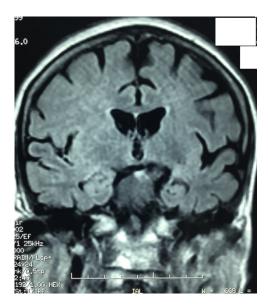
MRI after 14 days from admission.
